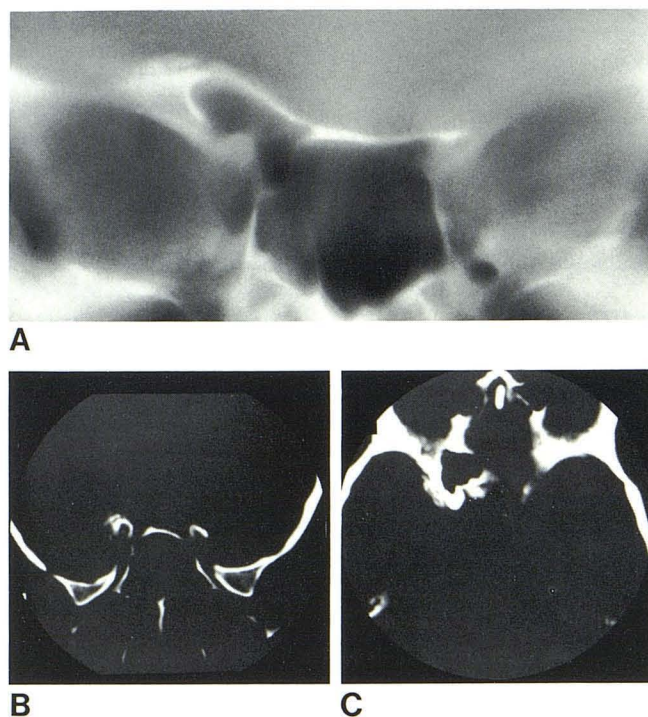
Case 2. Anteroposterior polytomogram (A) and high-resolution CT scans at bone window settings in coronal (B) and axial (C) views. Dense hyperostosis and pneumatization of right sphenoidal lesser wing. Subdural calcium or bone plaque along hyperostotic bone with dural lucent interface.
